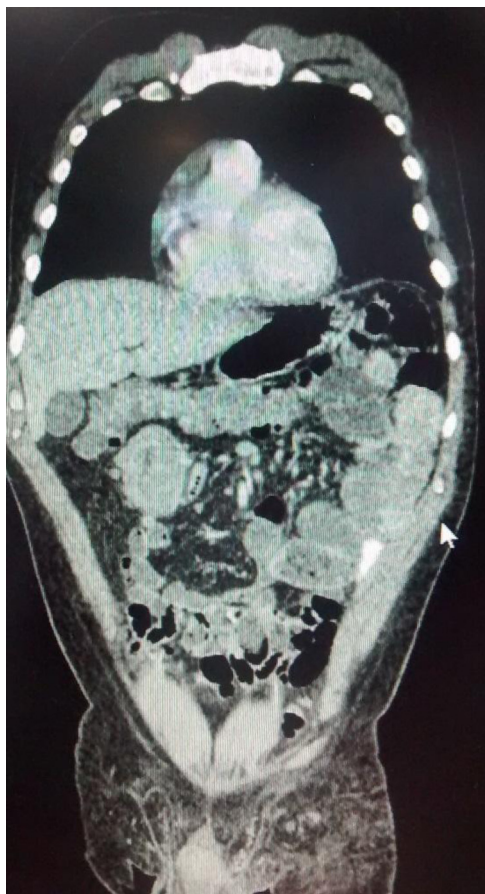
CT scan, coronal plane showing thickening of intestinal wall.
